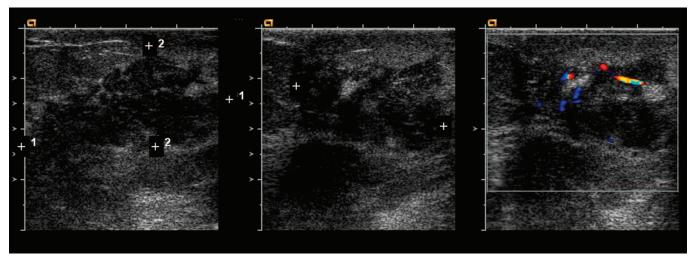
Ultrasonography of the right breast of a patient with GLM revealed an ill-defined mixed density mass with shadowing in the retroareolar region. The findings corresponded to the clinically palpable lump. Left, Transverse retroareolar view. Caliper distance 1 = 4.23 cm. Caliper distance 2 = 1.88 cm. Center, Sagittal retroareolar view. Caliper distance = 3.05 cm. Right, Sagittal retroareolar view. The mass demonstrated flow on power Doppler imaging.
